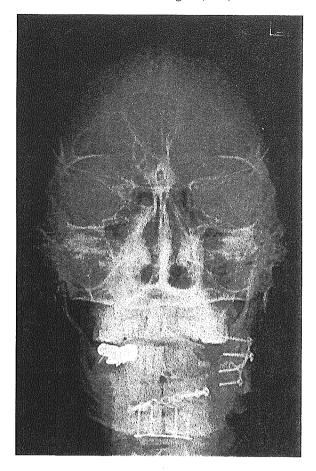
Radiograph of the reconstructed mandible.
